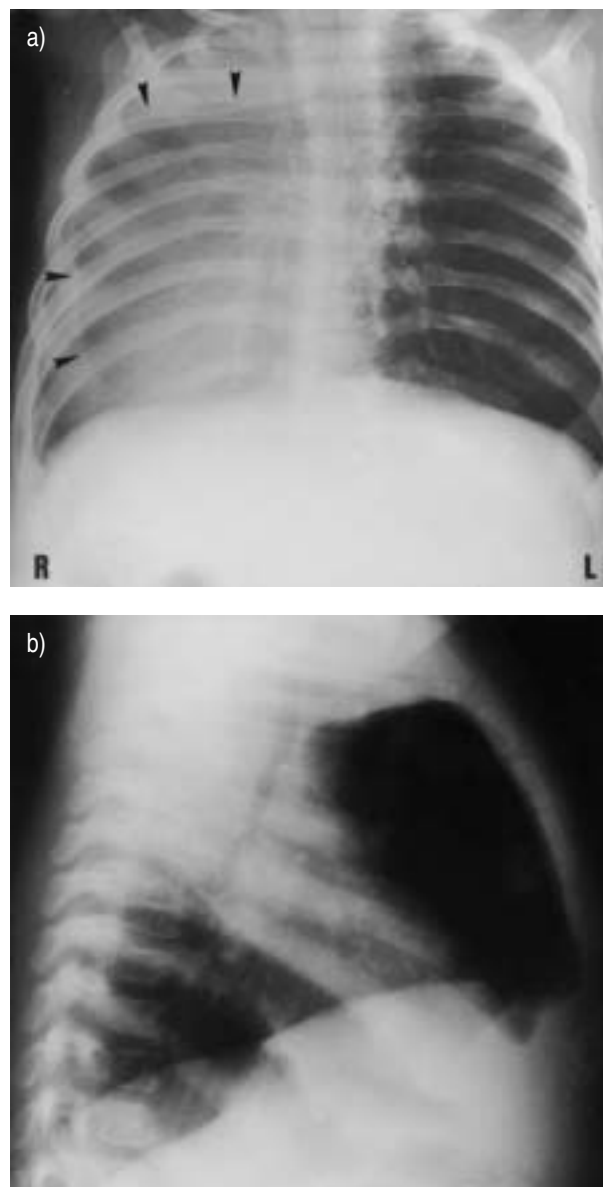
a) Anteroposterior and b) lateral chest radiograph.
